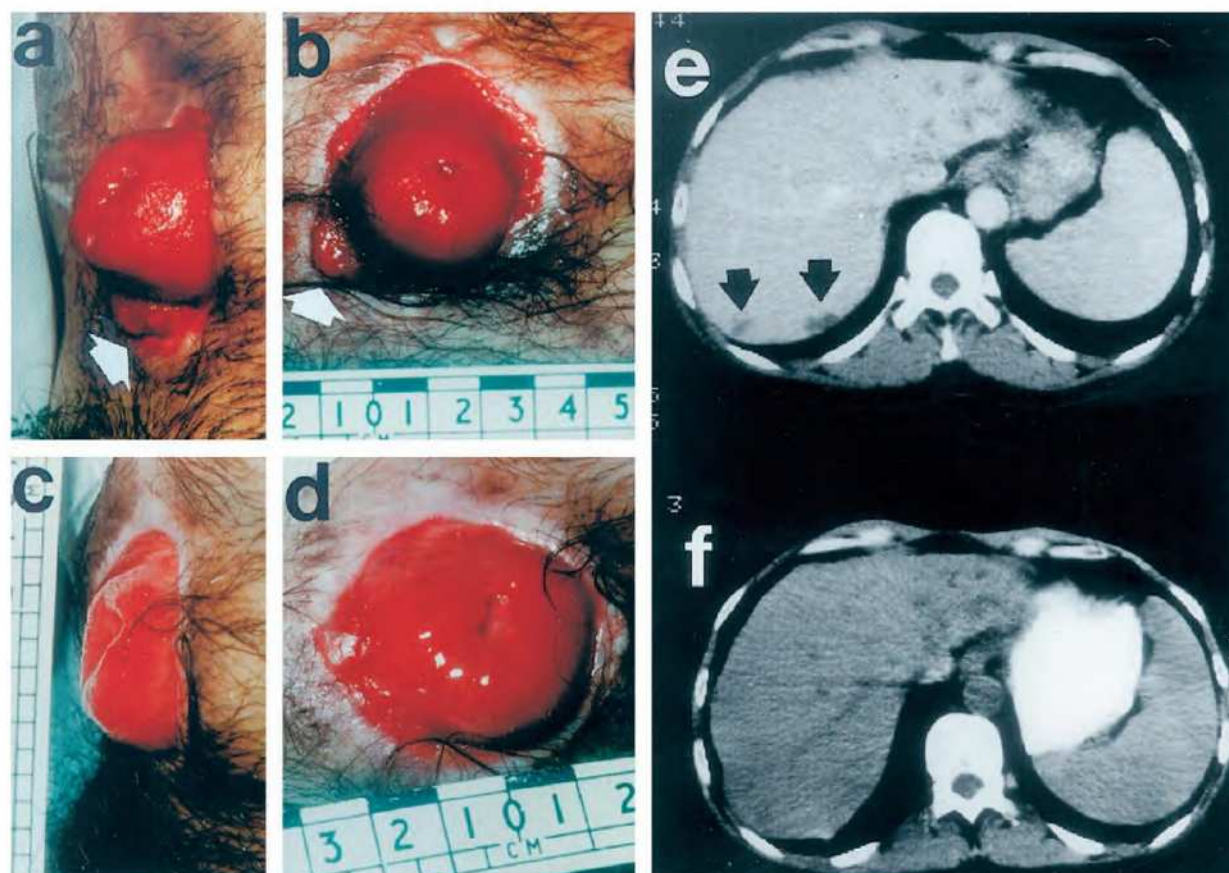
Response to treatment in patient 1. Stomal metastasis of rectal cancer (*a* and *b*) before and (*c* and *d*) 56 days after ADEPT therapy; a substantial reduction in the volume of tumor is seen. CT (*e*) showing hepatic metastases of rectal cancer (*arrows*) and resolution (*f*) 56 days after ADEPT.
